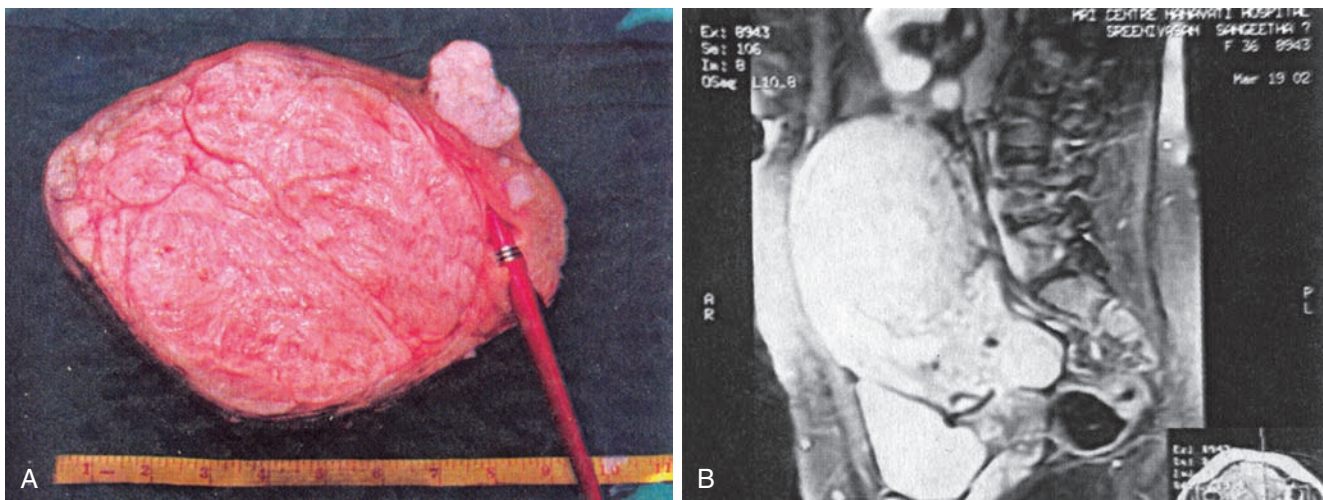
(A) Mirror image of fibroid seen on MRI. (B) MRI showing fibroid uterus.
